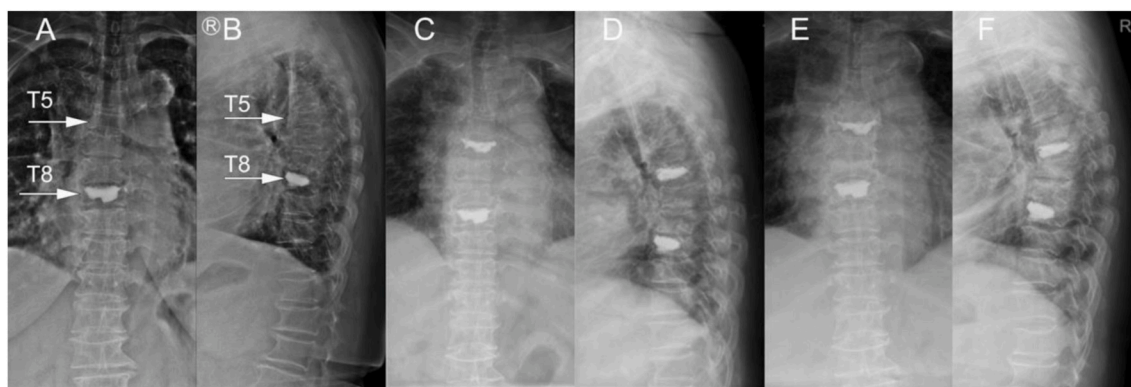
A 73 year-old female underwent PVP for a vertebral compression fracture (T8) two years ago. An accidental fall caused a fresh vertebral compression fracture (T5). PVP was performed in T5 with the Alliment® spinal bone cement. A & B. Preoperative T5 vertebra morphology and height in the anterior-posterior and lateral X-rays, respectively. C & D. Immediate postoperative vertebra morphology and height in the anterior-posterior and lateral X-rays, respectively. E & F. 1-year postoperative vertebra morphology and height in the anterior-posterior and lateral X-rays, respectively.
